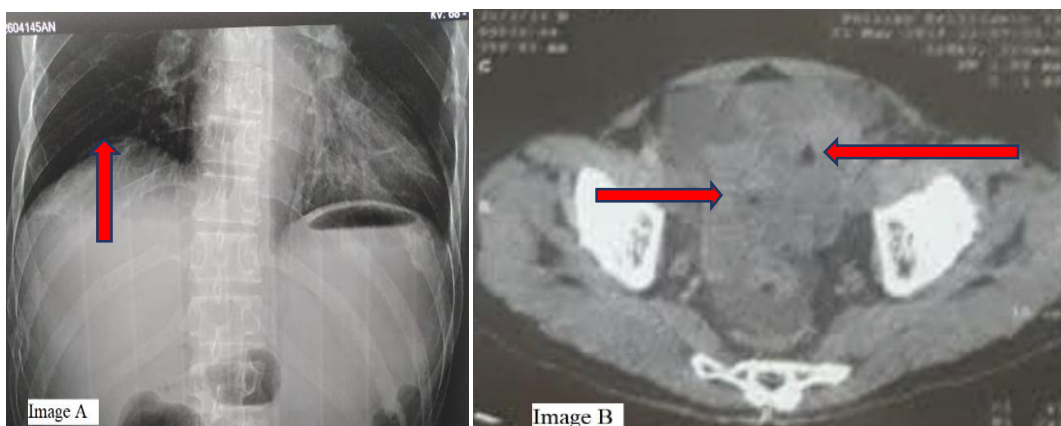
The X-ray of the abdomen without preparation showing subhepatic crescent clarity
